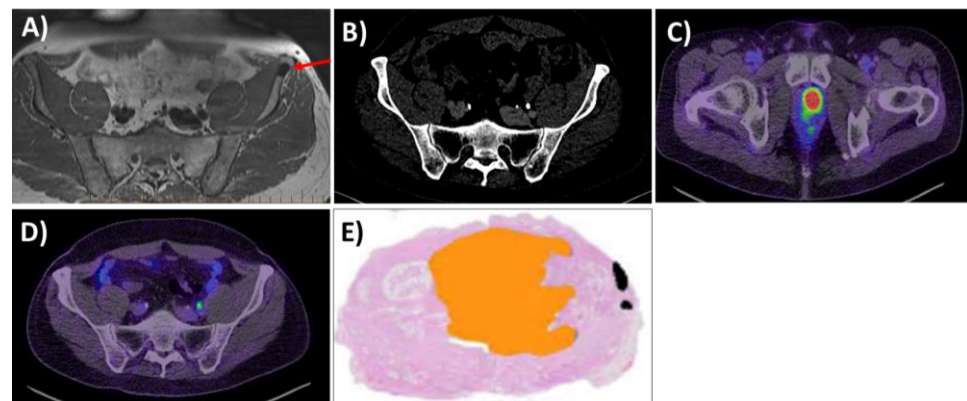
Clinical case from routine practice at the Peter MacCallum Cancer Centre (PMCC), where the use of PSMA PET/CT had dramatically changed therapeutic interventions. The patient presented with a PSA of 45 and a left Prostate Imaging Reporting and Data System (PIRADS) 5 lesion on MRI, with the biopsy confirming left GGG2 disease. The MRI and CT scans also showed a suspicious sclerotic lesion in the left iliac crest, which was concerning for bony metastases (A,B). The red arrow highlights the bony lesion in the left iliac crest. The bone appeared to show no apparent disease. Conversely, the PSMA PET/CT showed high PSMA avidity, with a maximum SUV (SUVMax) of 21.9 in the left prostate lesion and no avidity within the previously identified bone lesion (C,D). The patient proceeded to have a radical prostatectomy (RP) for localised high-risk PCa (E). At 3 years after the curative treatment, the patient's PSA remained undetectable.
